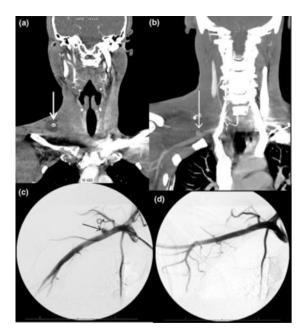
(a) Coronal view with FCBT right zone 1, (b) Coronal view of CTA showing subclavian artery pseudo-aneurysm, (c) Digital subtraction angiogram (DSA) confirming subclavian pseudoaneurysm, (d) DSA after endovascular stenting with resolution of aneurysm ²⁸
